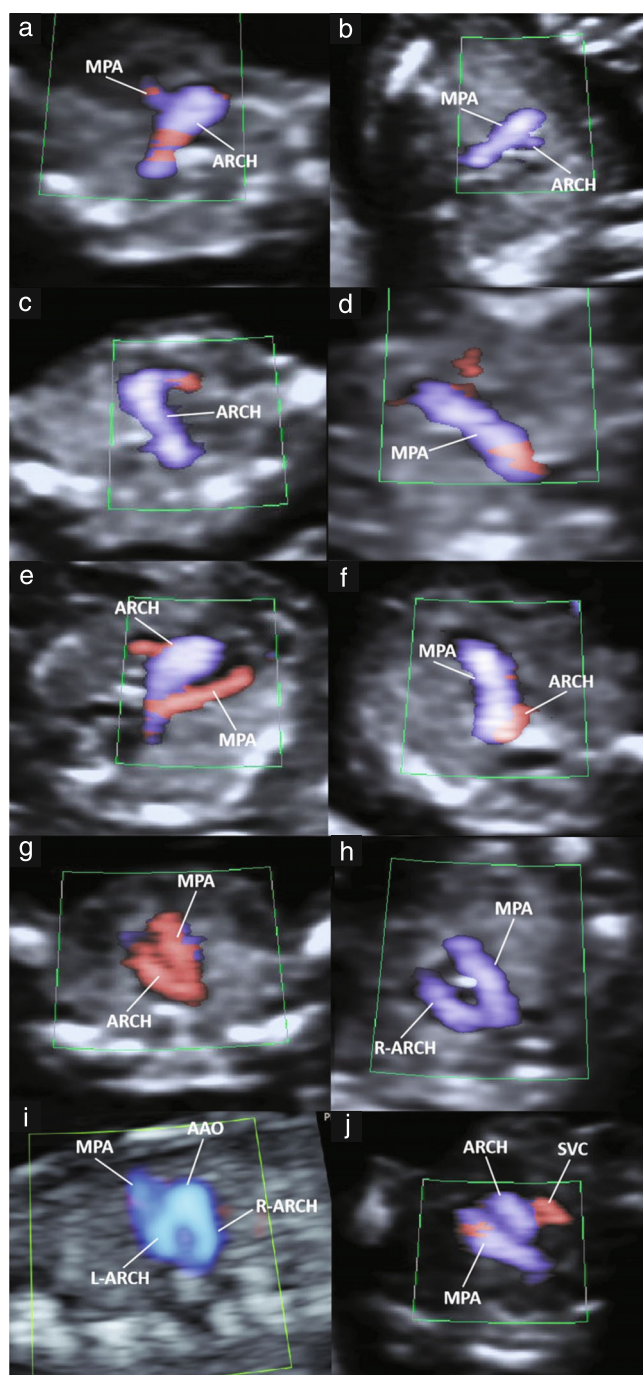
Three-vessel-and-trachea views on color Doppler imaging in first trimester, showing various types of congenital heart disease: (a) narrowed main pulmonary artery (MPA) blood flow; (b) narrowed aortic blood flow; (c) only aortic blood flow observed; (d) only MPA blood flow observed; (e) MPA stenosis with reversed blood flow; (f) aortic reversed blood flow; (g) MPA and aortic reversed blood flow; (h) U-shaped blood flow pattern; (i) O-shaped blood flow pattern; (j) superior vena cava (SVC) blood flow. AAO, ascending aorta; ARCH, aortic arch; L-ARCH, left aortic arch; R-ARCH, right aortic arch.
